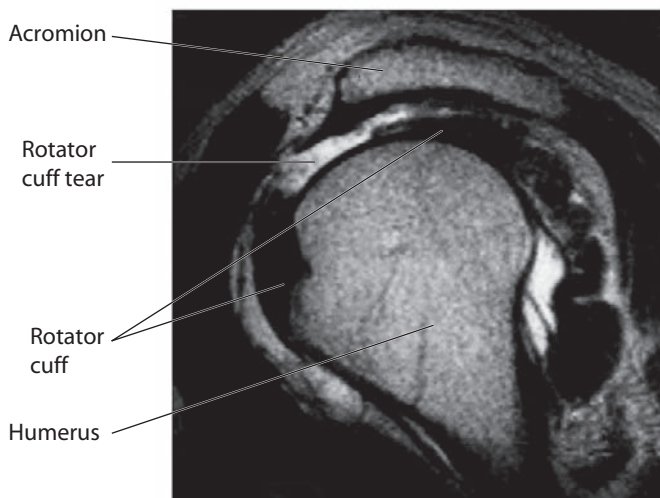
Magnetic resonance imaging (MRI) of the shoulder can be of great value to secure the correct diagnoses. MRI with contrast injected into the joint, i.e. MR arthrogram.
